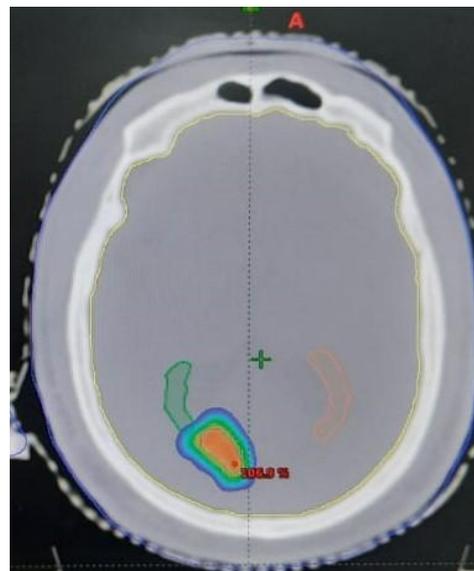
Radiotherapy planning CT scan shows dose colour wash with differential dose distribution (red colour with high dose coverage area and blue colour with low dose coverage area)
